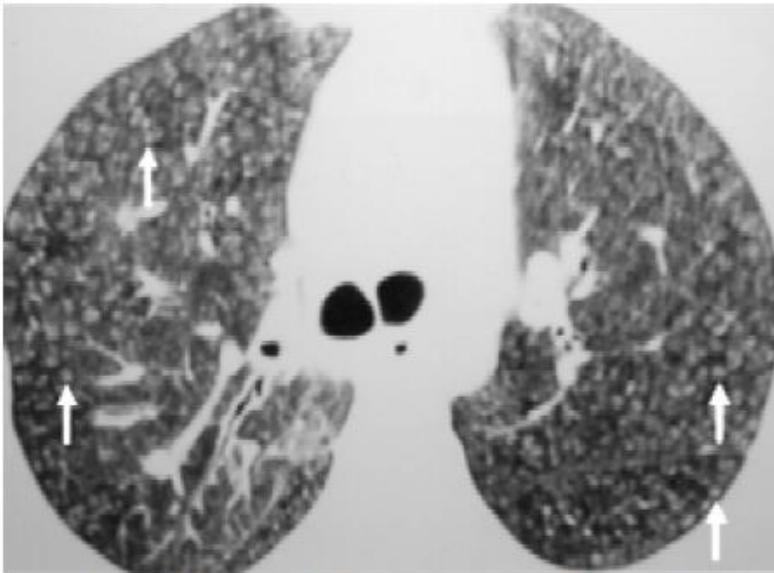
Axial high resolution CT image (window width 1,000, level -700) in a patient with *Aspergillus*-induced subacute hypersensitivity pneumonitis. High resolution CT reveals the characteristic appearance of diffuse, bilateral poorly defined, ground-glass centrilobular nodules (arrows).
